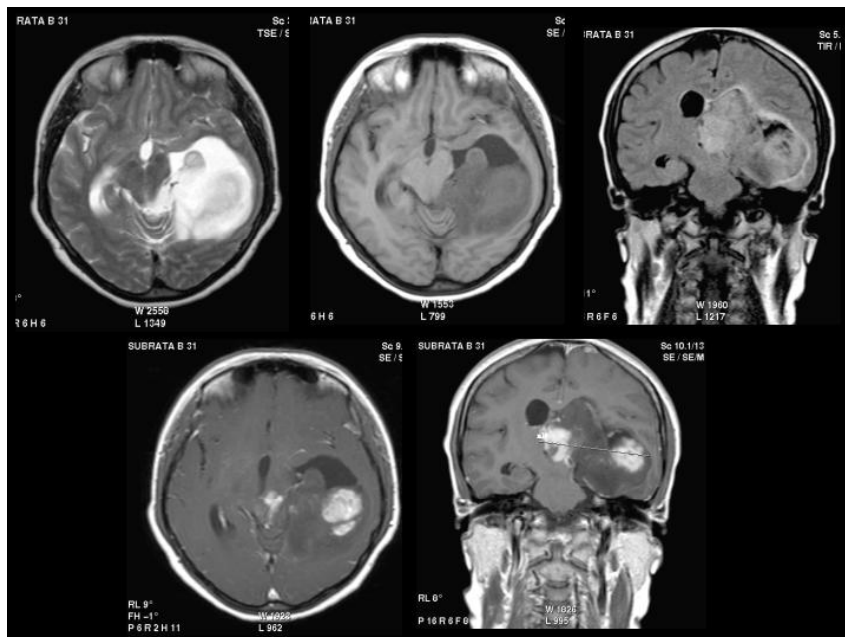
MRI shows large bulky, enhancing intra-ventricular mass in left temporal horn infiltrating into temporal lobe suggesting high grade neoplasm
